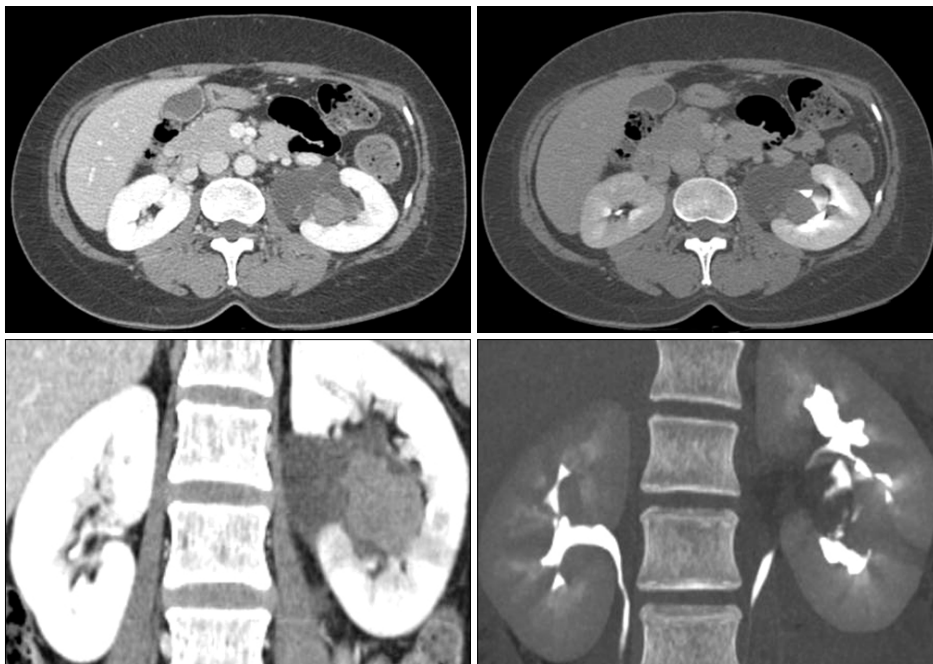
Computed tomography (CT) scan of the abdomen shows a large heterogeneous and well defined mass measuring 6.3x4.0cm. Axial and coronal contrast-enhanced CT image reveals a solid cystic mass growing in the left renal pelvis containing a 3.2x3.2cm heterogeneous enhancing solid portion and suspicious renal parenchymal invasion with several wedge shaped densities. Axial and coronal CT image at the excretory phase shows deviating and mass effect to the left urinary tract rather than dilatation and no contrast passage delay or disturbance on the left urinary tract.
